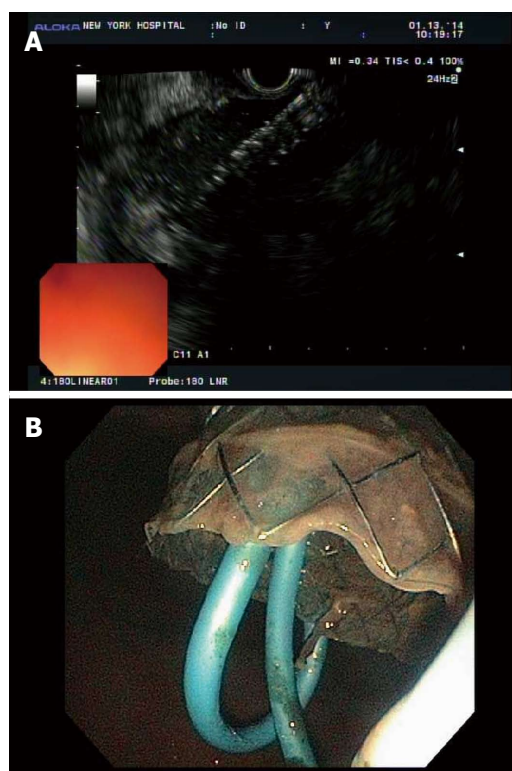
Endosonographic visualization (A) and endoscopic visualization (B) of a biliary fully covered self-expanding metal stent being deployed into walled-off pancreatic necrosis.
